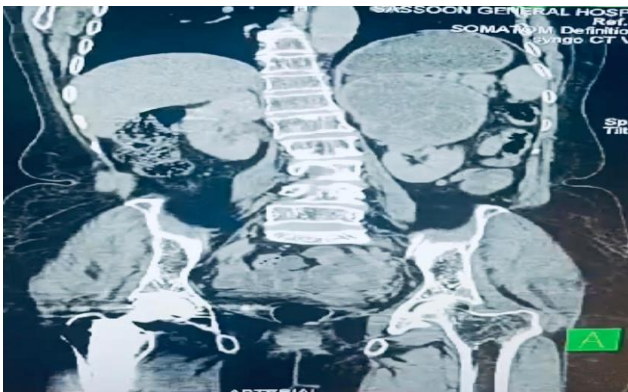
CT coronal section showing tumor above left kidney not separately visualised from left adrenal gland (tumour marked with an arrow).
